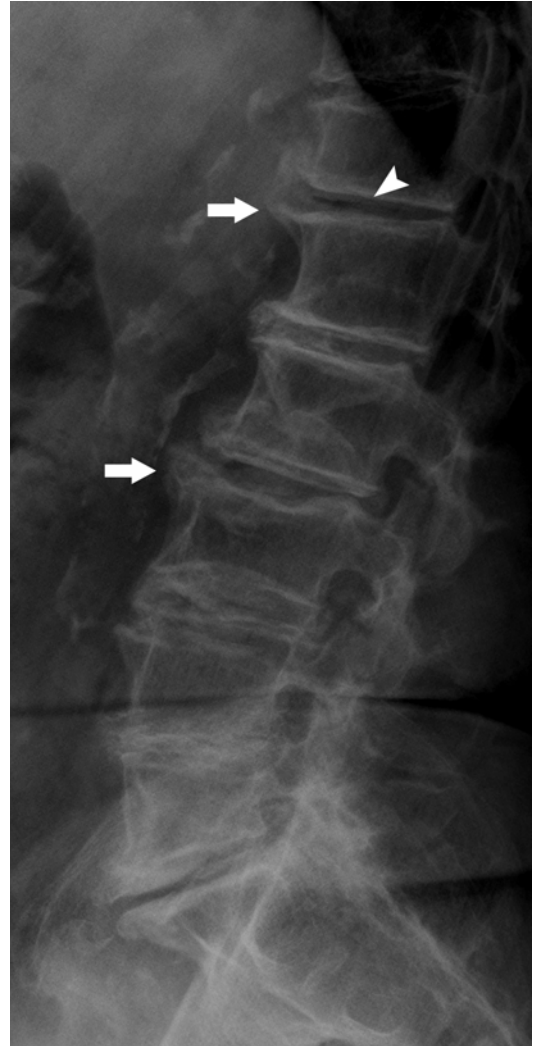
Degenerative disk disease at multiple levels. Lateral radiograph shows disks narrowing with osteophytes (*arrows*) and vacuum phenomenon (*arrowhead*)
